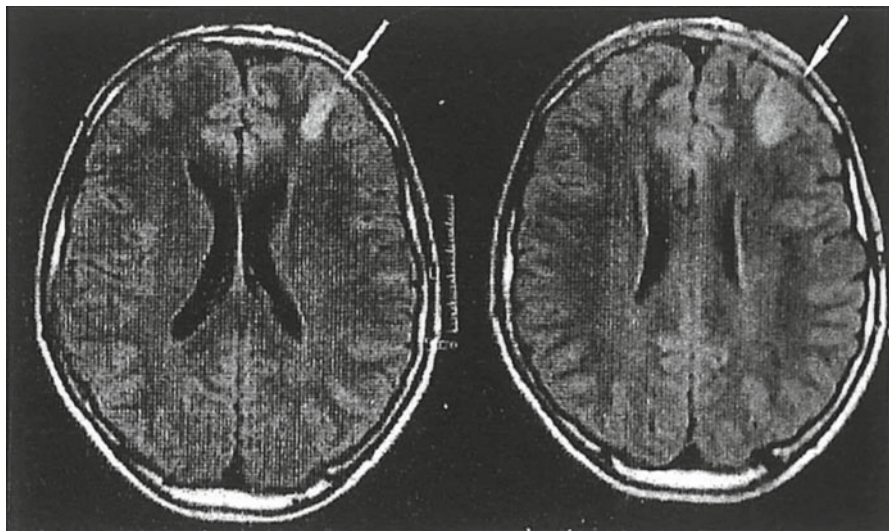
MRI FLAIR: left anterior hypersignal (cortical dysplasia). Nocturnal frontal lobe epilepsy. Published in Crespel, A., et al. *Atlas of Electroencephalography Volume 2: The Epilepsies, EEG and Epileptic Syndromes*. With permission of John Libbey Eurotext
